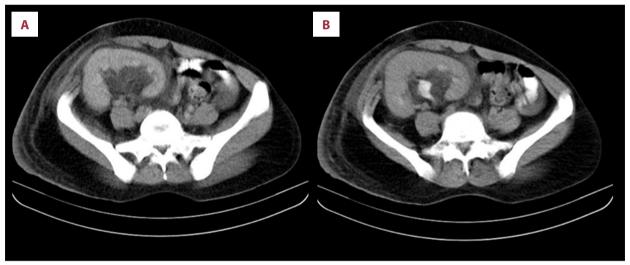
(A, B) Contrast-enhanced abdominal and pelvic computed tomography (CT) scan of a 32-year-old woman showing enlargement of the transplanted kidney and no hydronephrosis.
